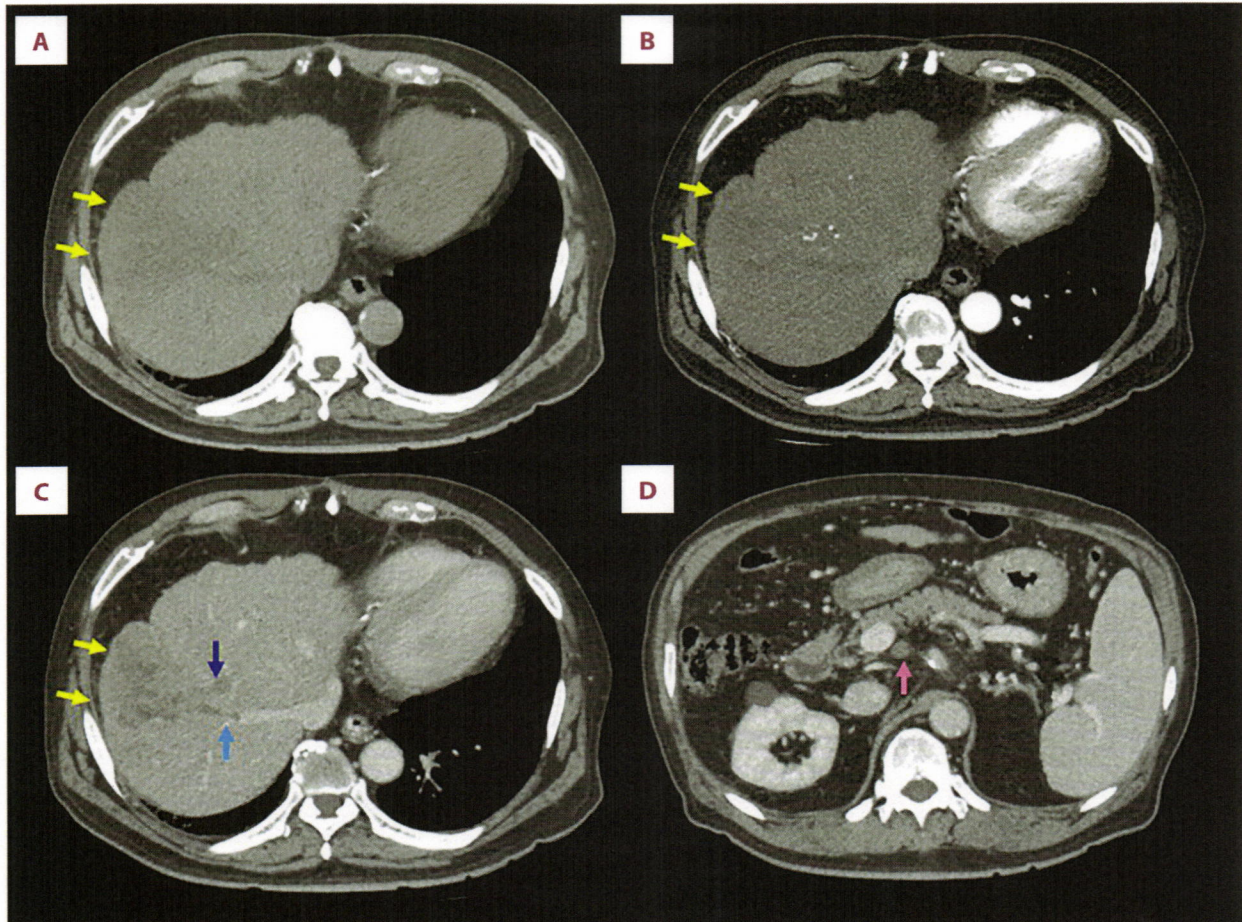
Dynamic CT findings 18 days after the initial diagnosis. Dynamic CT images are shown in the plain phase (A), arterial phase (B), portal phase (C), and equilibrium/transitional phase (D). The hepatic tumor (yellow arrows) had enlarged to 75 mm (A-C), with tumor thromboses clearly observed in the right HV (C, blue arrow) and the anterior branch of the PV (C, purple arrow). Dynamic CT did not show early wash-in or wash-out in the hepatic tumor (yellow arrows). Additionally, a new solitary and swollen lymph node was detected dorsal to the PV trunk (D, pink arrow). CT – computed tomography; HV – hepatic vein; PV – portal vein.
